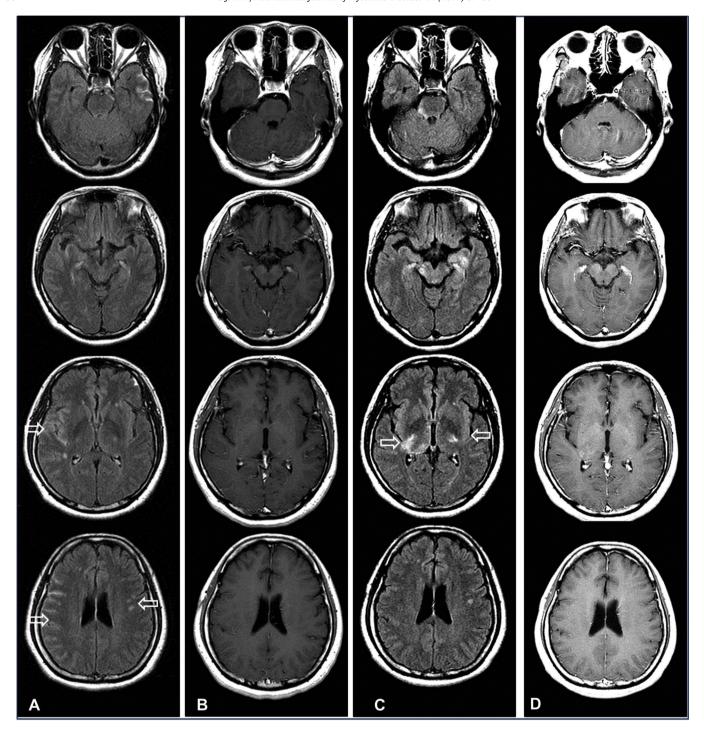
(A) Hospital day 1: Contrast-enhanced FLAIR images showing slight leptomeningeal enhancement in the right temporo-parietal region (arrows). It is difficult to differentiate tuberculosis meningitis from other diseases showing high signal intensity within the sulci. (B) Hospital day 1: Contrast-enhanced T1-weighted images. (C) Hospital day 60: Contrast-enhanced FLAIR images conspicuously showing high signals in right peripontine and left medio-temporal regions (arrows). (D) Hospital day 60: Contrast-enhanced T1-weighted images. The contrast-enhanced T1-weighted images showed no evidence in the same areas.
